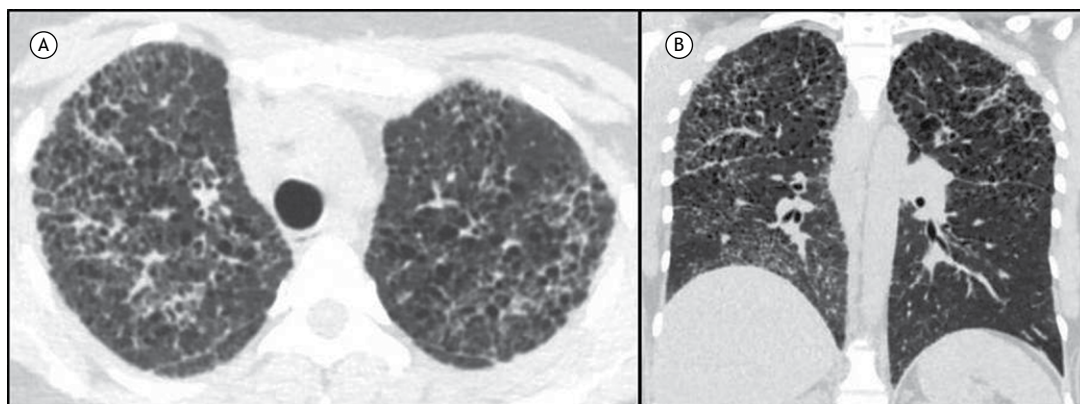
Chest CT scans. In A, axial reconstruction demonstrating several thin-walled, cystic structures associated with interlobular septal thickening and pulmonary micronodules. In B, coronal reconstruction showing the cranial distribution of the lung cysts. The patient in question was a 38-year-old female and was diagnosed with multiple myeloma, renal failure, and lung involvement associated with light-chain deposition disease.
